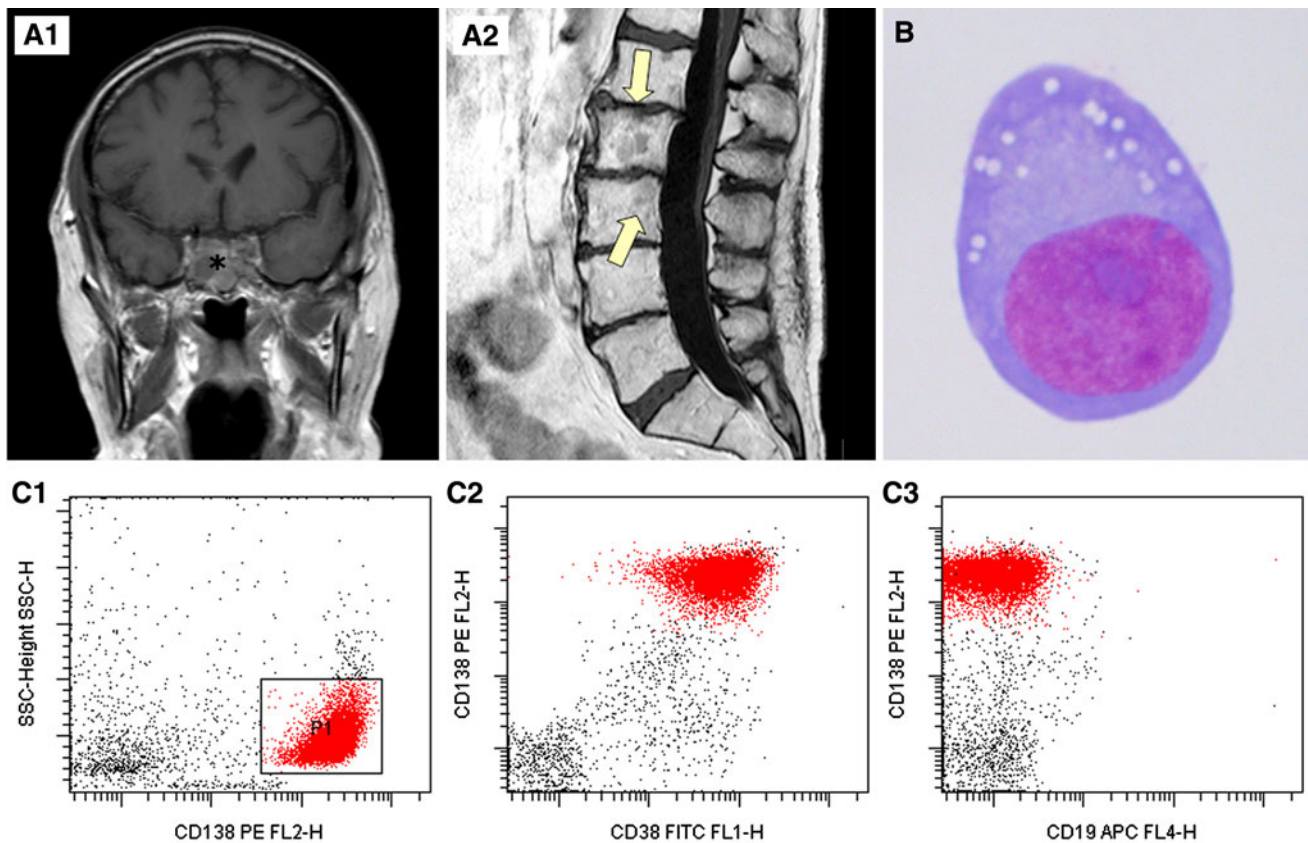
Studies from presented patient. a T1-weighted gadolinium-enhanced MRI of a1 brain and a2 lumbosacral spine. Pathologically enhancing multiple myeloma lesions are visible in the sphenoid sinus (*asterisk, a1*) and lumbar vertebrae (*arrows, a2*). No pathological gadolinium-enhancement of the nerve roots or meninges is visible.
